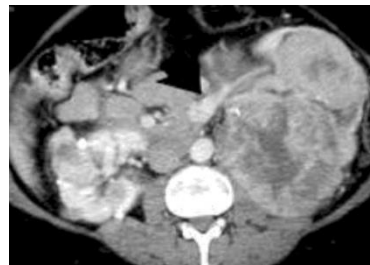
Multifocal renal cell carcinoma on contrast-enhanced CT scan
